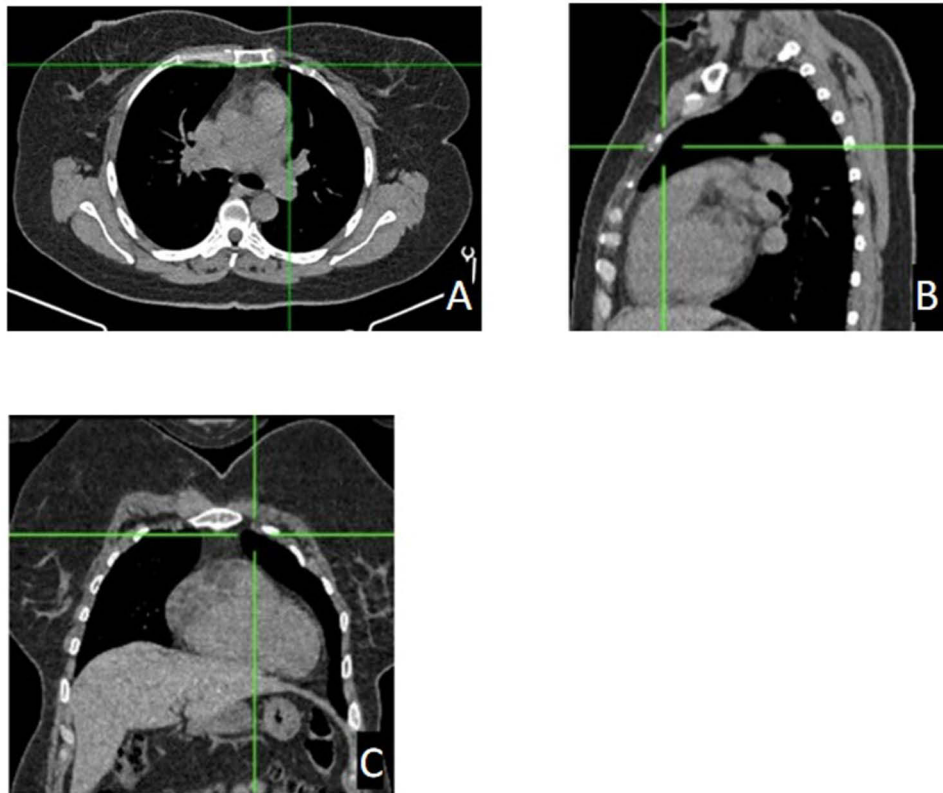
Chest Computed Tomography. At the time of admission, a chest CT scan performed on 12 May 2025 demonstrated: CT findings were consistent with bilateral bronchitis, linear pneumofibrosis, and bronchopulmonary lymph node adenopathy. However, no calcifications were noted in the parasternal region at the sites of previously resected osteophytes and costal cartilages. (A) Axial slice. (B) Sagittal slice. (C) Coronal slice.
